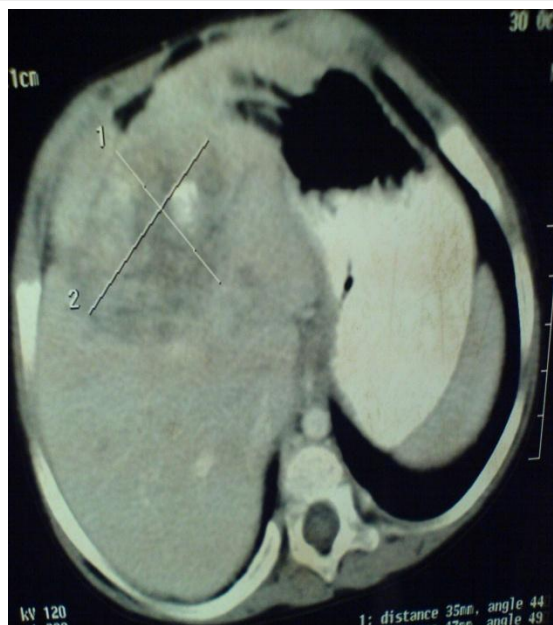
CT image showing Hepatoblastoma of the Right lobe
